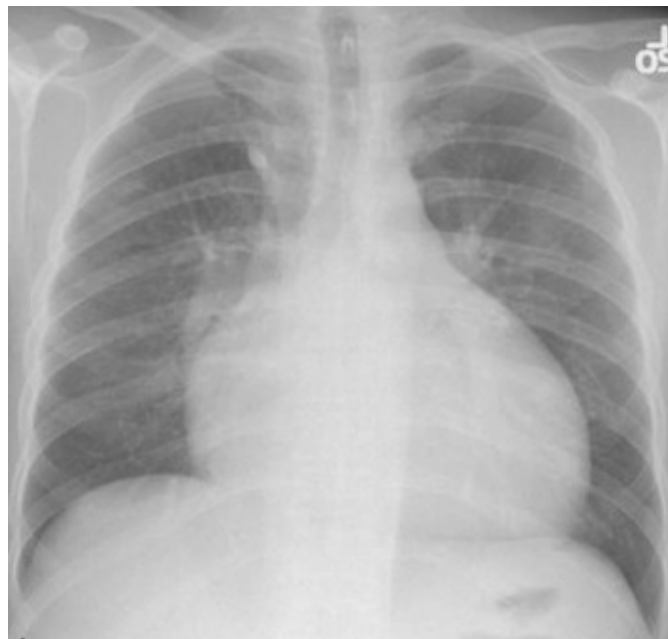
Bedside chest radiograph showing enlargement of right side of heart and large pulmonary arteries
